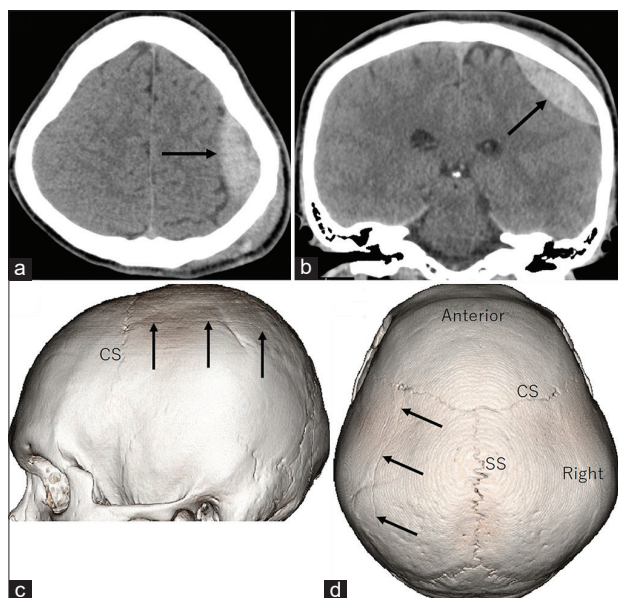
Axial (a) and coronal (b) computed tomography scans at presentation show a biconvex hematoma with 18-mm thickness in the left high parietal region (arrow). Lateral (c) and superior (d) views of the three-dimensional computed tomography scans show a linear fracture in the left parietal bone passing parallel to the sagittal suture. CS: coronal suture.
